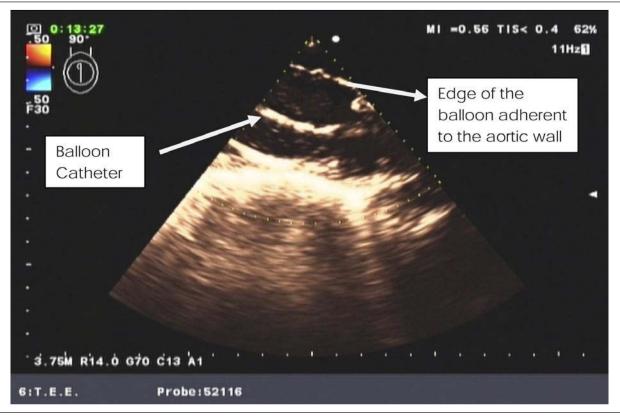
Intraoperative transesophageal echocardiographic image of the balloon catheter fully expanded within the descending thoracic aorta stent.
